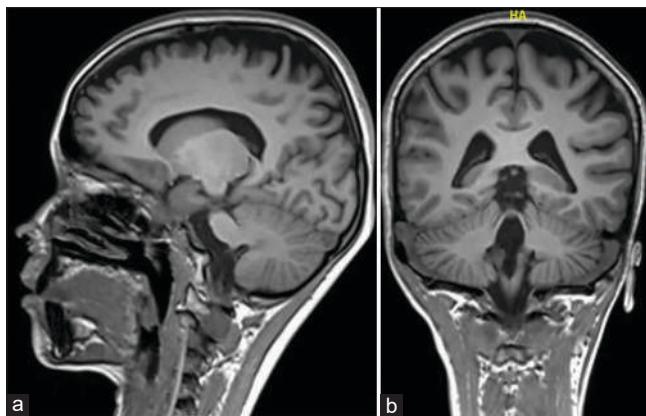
Magnetic resonance imaging brain showing mild diffuse cerebral atrophy. (a) Sagittal plane, (b) Coronal plane
